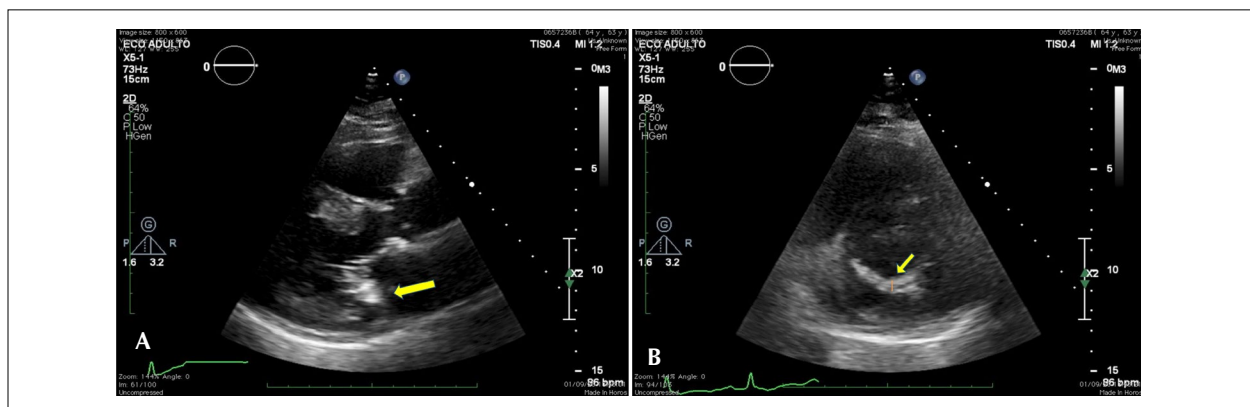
Two-dimensional evaluation of mitral annular calcification, which can be identified on the parasternal longitudinal projection as increased brightness intensity in the two-dimensional image (Panel A, yellow arrow). It can be quantified by its extension or its thickness on the parasternal short-axis projection (Panel B, yellow arrow and measurement line).
